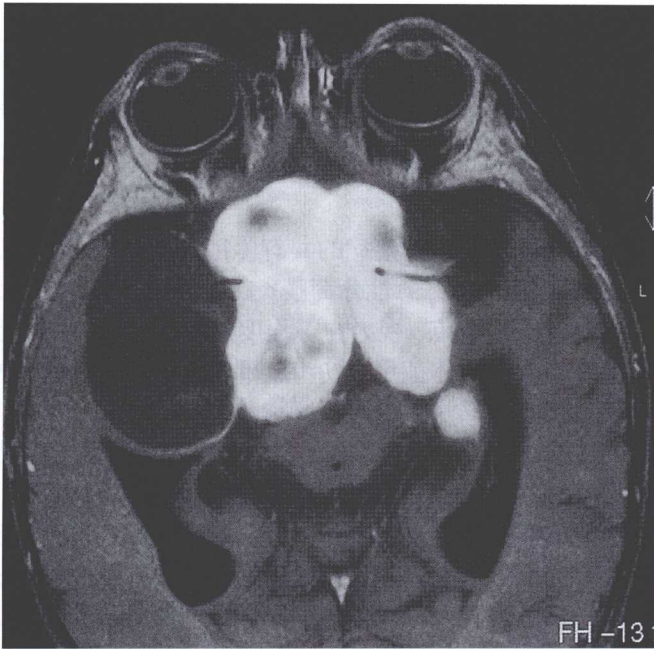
Axial enhanced MRI scan showing a mass involving the optic chiasma and extending down the optic nerves and tracts.
